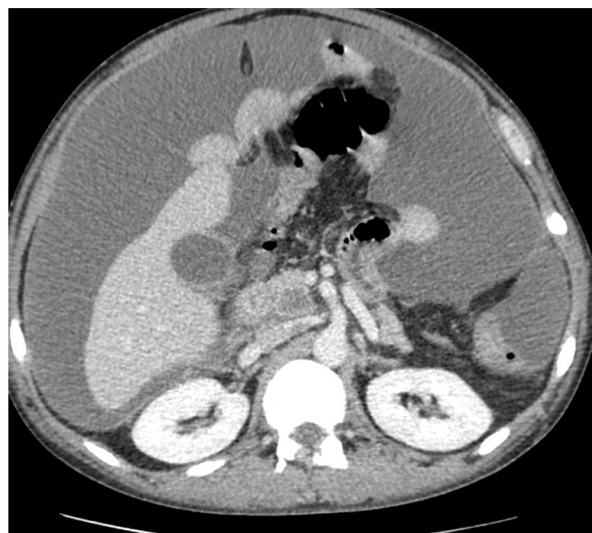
Hypoenhancing 1.8 cm nodule within the pancreatic uncinate seen on the initial CT scan, Abdomen Pelvis.
